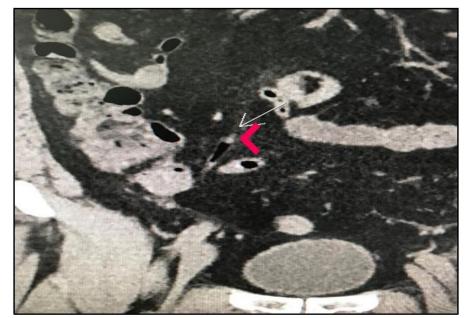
Localization of the appendix in a reconstruction of a coronal CT scan. Red and white arrows identify the caecal appendix with thin walls.
